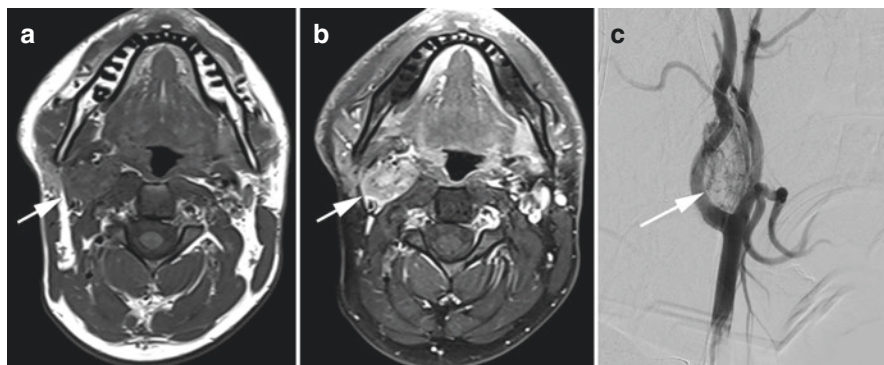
Carotid body paraganglioma. Right carotid body paraganglioma on MRI, with T1 pre-contrast (a), T1 postcontrast (b), and pretreatment DSA (c) showing an avidly enhancing mass (arrow) splaying the internal and external carotid artery
